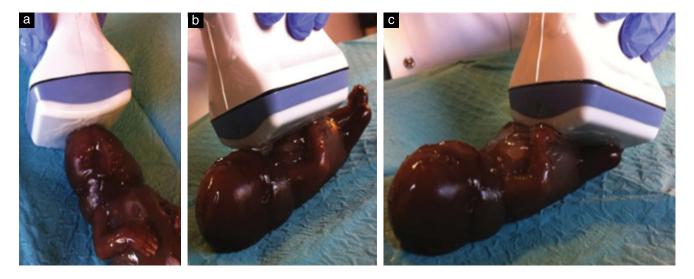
Postmortem ultrasound examination performed with a high-frequency linear probe (RSP 6-16) in a 14-week fetus terminated for Down syndrome and cystic hygroma. In (a) the probe is positioned on the anterior fontanel to image the fetal brain. In (b) and (c) the probe is on the thorax and abdomen, respectively.
